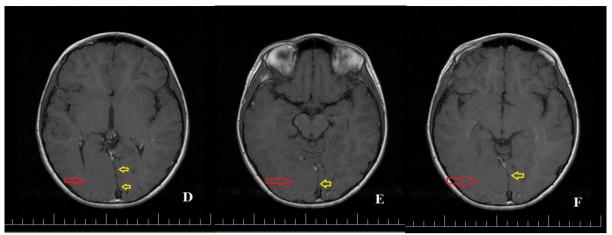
Image D,E and F. T1-weighted+contrast axial MRI of brain showing cortical dysplasia and mild enlargement of the right occipital lobe (red arrows) with mild displacement of the midline of the brain (yellow arrows) and no enhancement of the dysplastic structure.
